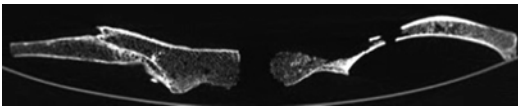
CT scan axial plane multiplanar reconstruction
